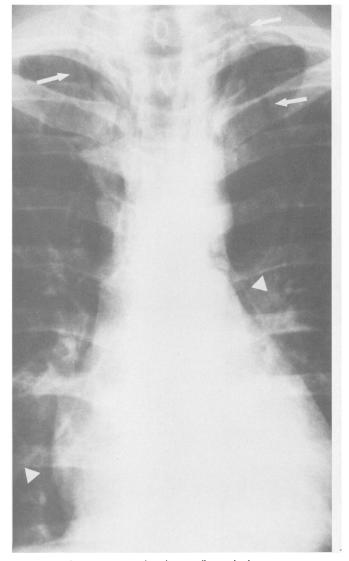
An anteroposterior chest radiograph shows pneumomediastinum (arrowheads) with dissection of air into the subcutaneous tissue planes of the neck (arrows).
